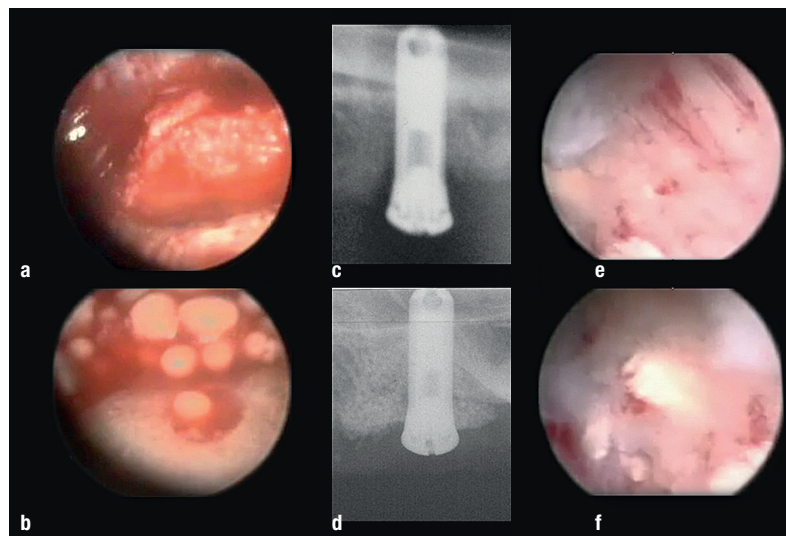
Intra-op situation: augmentation with autologous bone material (a) and tricalcium phosphate augmentation material (b). Radiographic findings: pre-op (c) and post-op site (d) on the tooth film, clear filling of the defect. Re-entry after four months: implant surface covered by bone (e) with residue of bone replacement material (f).
